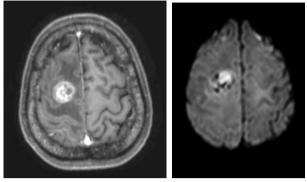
Contrast-enhanced and diffusion-weighted MRI demonstrating an avidly enhancing right frontal mass with surrounding vasogenic edema and restricted diffusion within the lesion, respectively.
